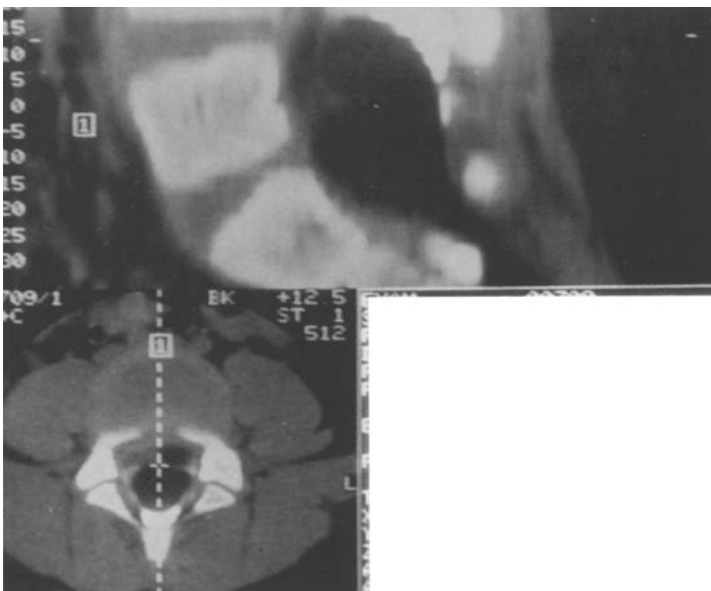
Same patient: Sagittal reconstruction of the myelo-CT demonstrating the intraspinal extension of the lipoma with subcutaneous growth and tethering of the medullary conus.
